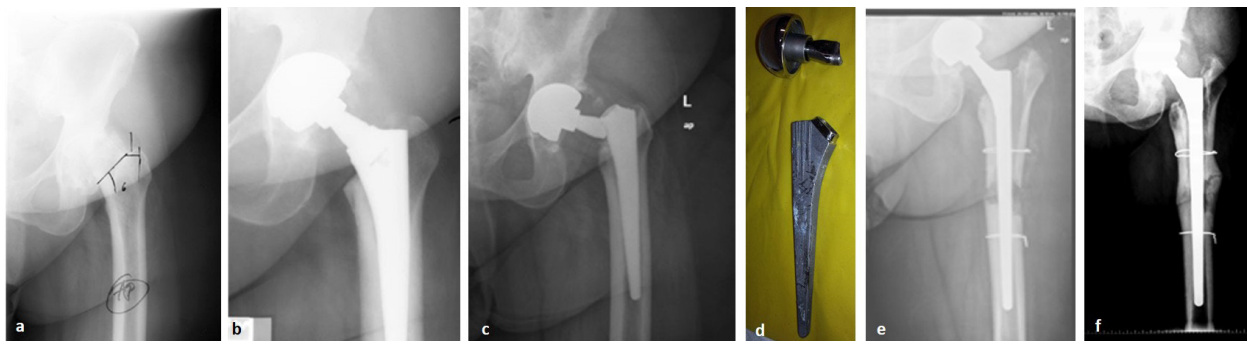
(a) preoperative x-ray of a 44-year-old patient with osteoarthritis, hip dysplasia and slipped capital femoral epiphysis, (b) 2-month postoperative x-ray after THA implantation, (c) fracture of the femoral neck at 4 years postoperatively, (d) intraoperative photo of the broken implant, (e) 3-month postoperative x-ray after revision surgery with a Wagner type stem and extended osteotomy and (f) last follow up x-ray at 3 years post-revision.
